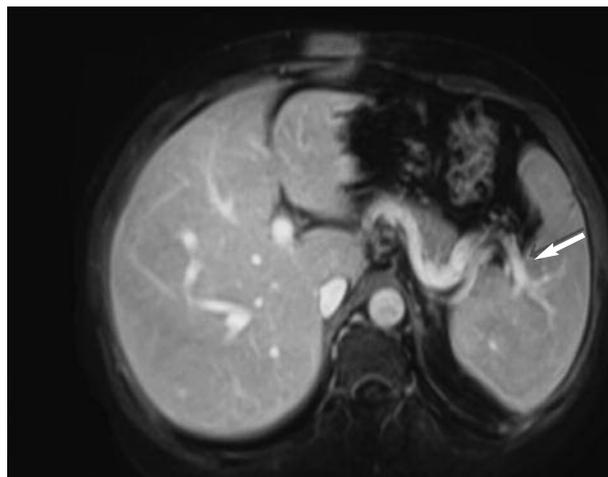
MRI angiography of the portal system; mildly dilated splenic vein (arrow).
